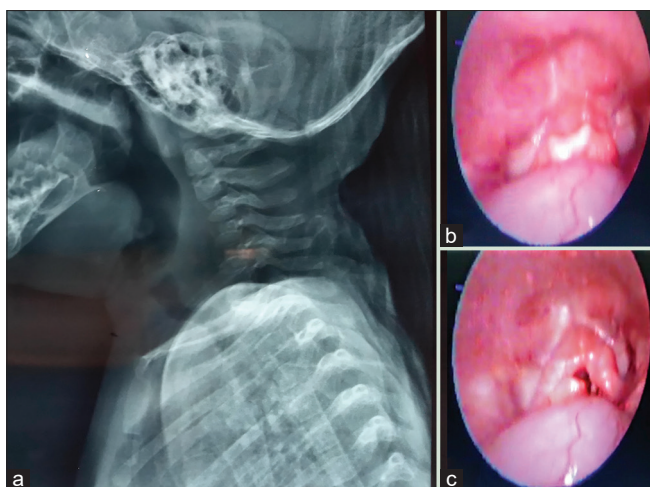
(a) X-ray neck showing hyperdense protrusion above the epiglottis, (b and c) Nasendoscopic view showing the glottic opening in the closed and open state
